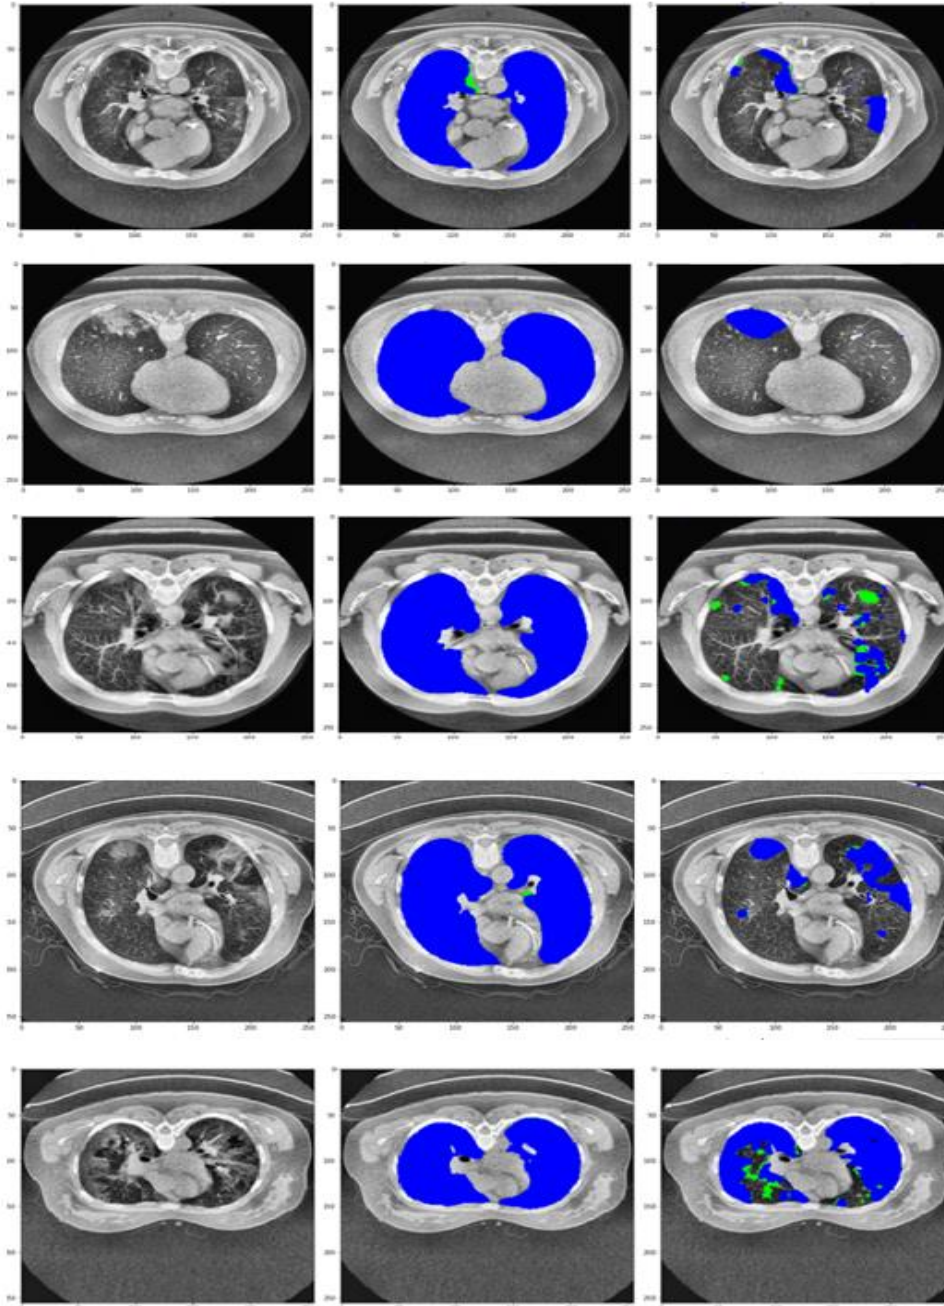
The rows display five samples (patient 1, patient 3, patient 4, patient 5, and patient 9) obtained from the COVID-19 CT segmentation³⁷ test dataset. The columns consist of the following: the original images are displayed on the left side. At the same time, the overlays between the predicted lung masks and the reference lung masks are shown in the center column. Lastly, the overlays between the predicted COVID-19 lesion masks and the reference COVID-19 lesion masks are displayed in the right column. The reference masks are shown in green, while the anticipated masks generated by the ECGANCOVID system are represented in blue.
